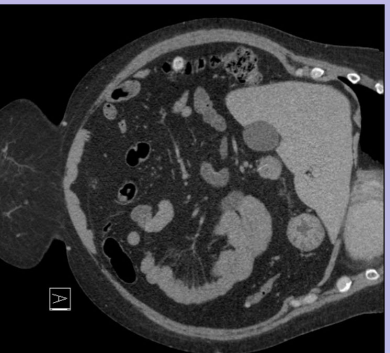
Computed tomography with contrast revealing foreign body identified in antrum of stomach
